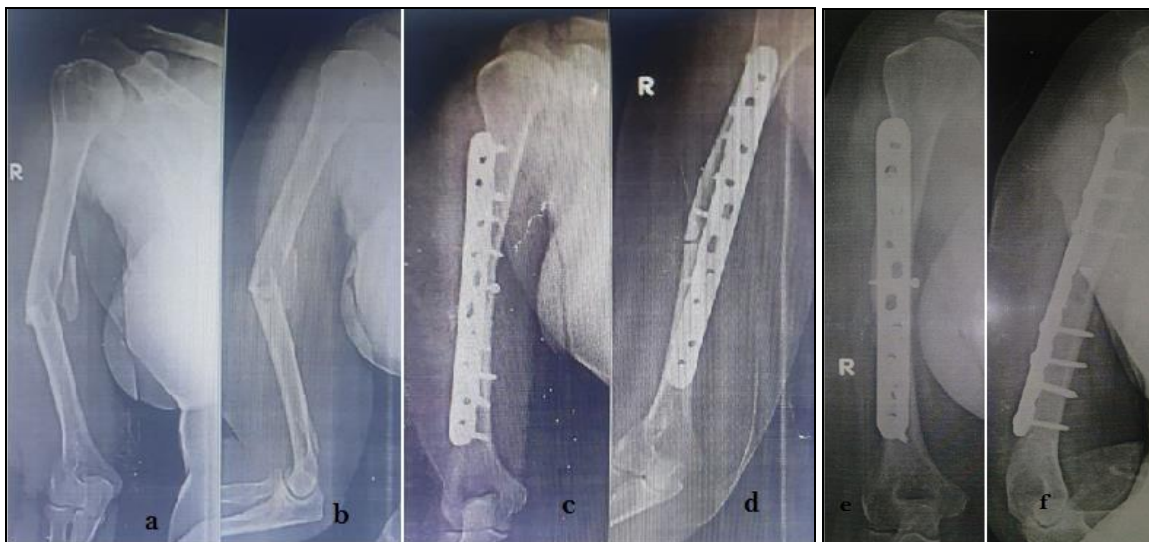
a, b: preoperative radiograph showing humerus shaft fracture c, d: immediate post-operative radiograph with ORIF with dynamic compression plate e, f: radiograph showing complete healing of fracture at final follow up
